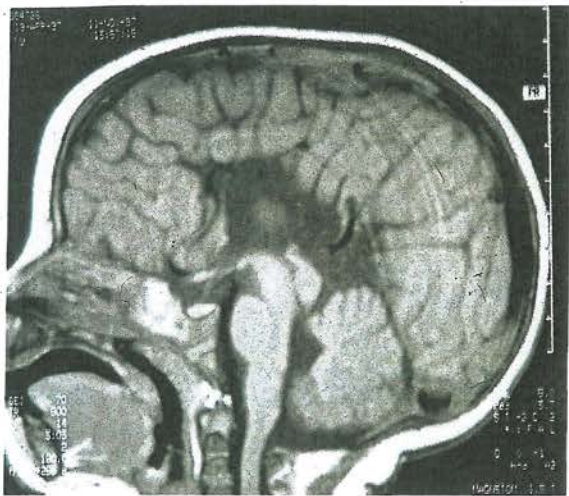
Sagittal MRI scan showing absence of the corpus callosum
